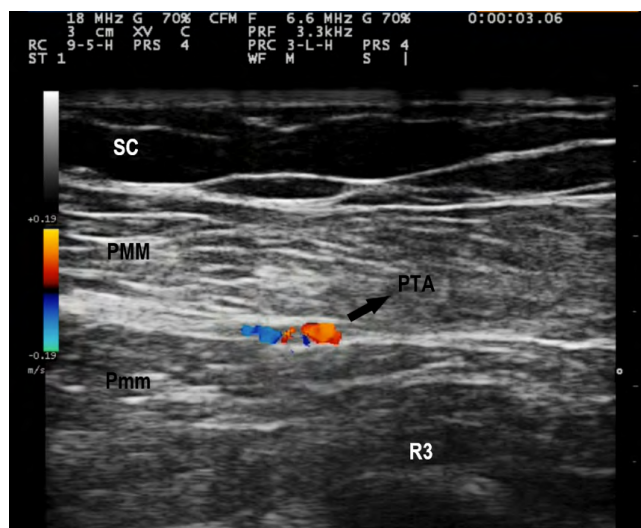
Doppler sonographic view of the thoracoacromial artery.
